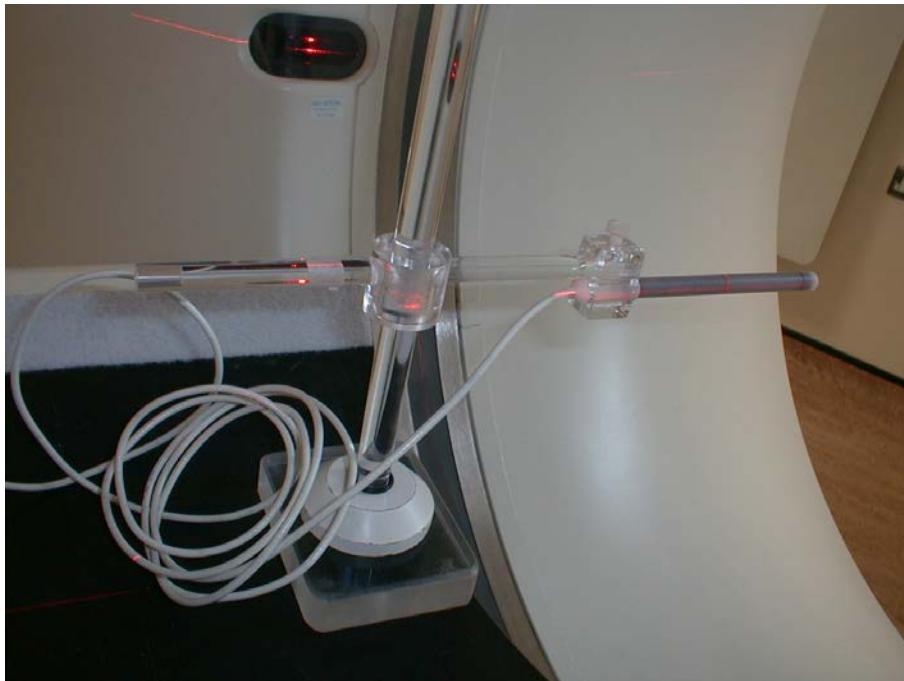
Arrangement for the measurement of the CT air kerma index free-in-air; $C_{a,100}$. The chamber is clamped in a specially designed support and aligned so that it is coaxial with the scanner rotation axis and that its sensitive volume is bisected by the scan plane. In this particular example, alignment has been achieved with the aid of laser lights. The cable is shown coiled in the demonstration photograph, but in an actual situation this would not be the case.
